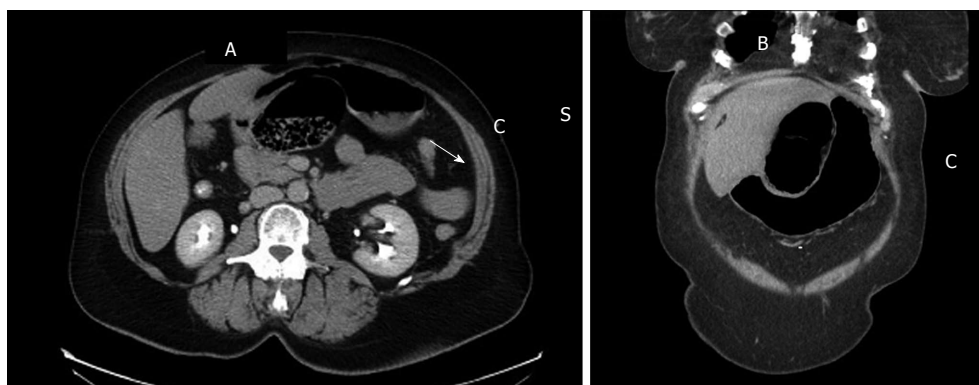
Computed tomography of abdomen and pelvis showing a loop of distended colon within lesser sac without bowel ischemia or perforation. Radiological features include: (1) the cecum herniated (C) into the lesser sac behind the stomach (S) (A and B); (2) the presence of mesentery (white arrow) between the portal vein and inferior vena cava (A); and (3) the presence of gas or fluid in the lesser sac with its 'beak' directed toward the foramen of Winslow (B).
